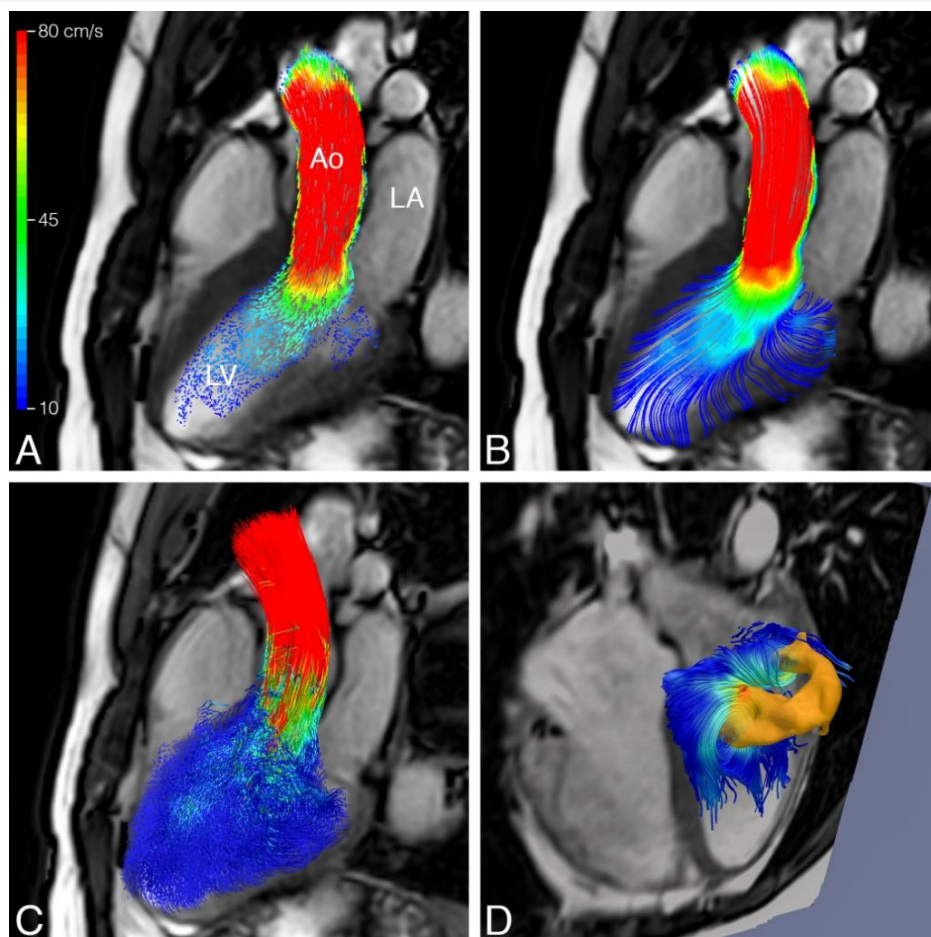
Visualization of left ventricular systolic blood flow using 4D flow MRI in a healthy volunteer (24 year old man). In A, blood flow velocity is displayed by color-coded vector glyph representation. Direction and velocity magnitude are presented by vector size and color. In B, a streamline representation is presented and C shows a pathline representation. Isosurfaces can be used to display flow structures with a common property, such as vorticity. In D, a ring-shape vortex is displayed in late diastolic LV filling in the same volunteer. Vortex extraction is performed using Eulerian vortex core analysis. The vortex ring is displayed with streamlines superimposed. LA: left atrium, LV: left ventricle, Ao: Aorta.
